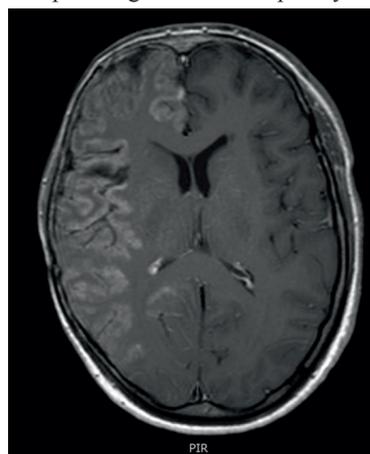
MRI showing vast involvement of the right cerebral hemisphere with no tumor recurrence.
